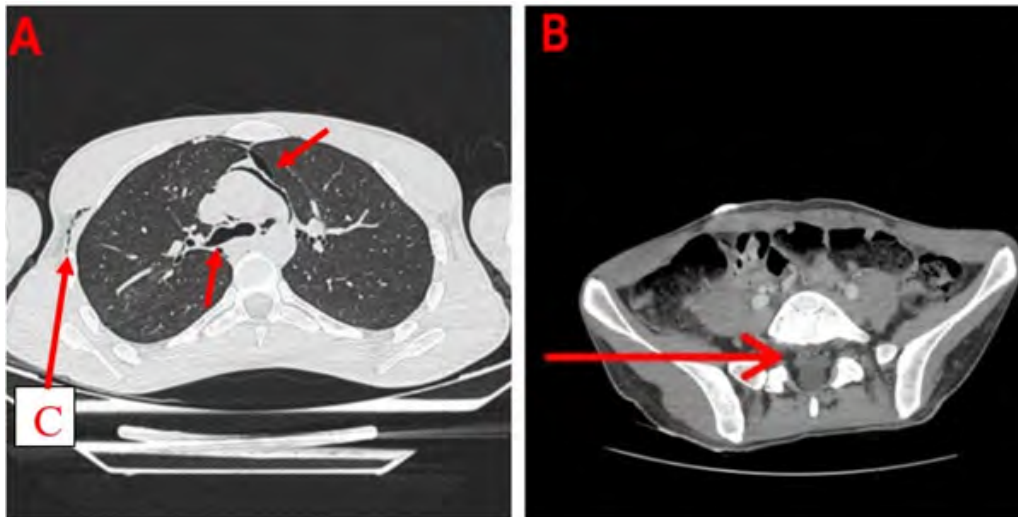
computed tomography showing a pneumomediastinum (A), with subcutaneous emphysema (C) and pneumorrhachis (B).
